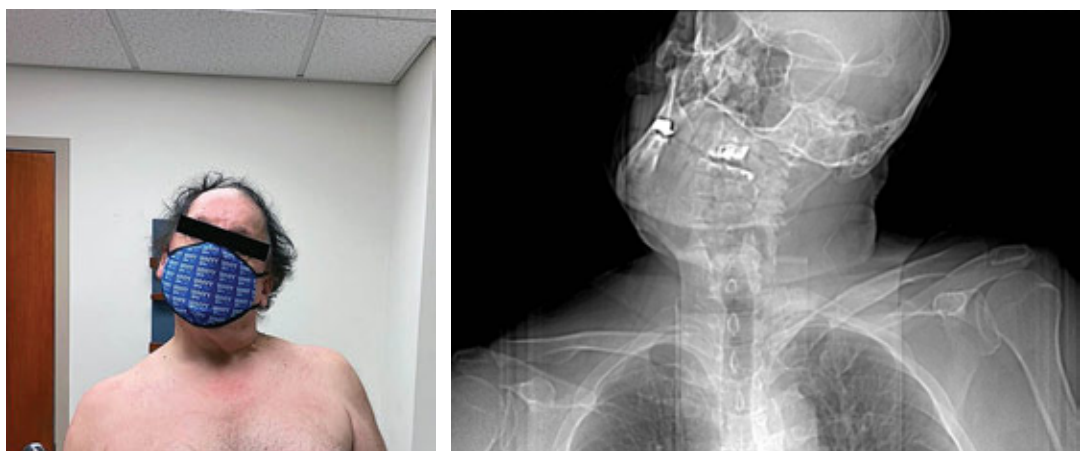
Pre-operative clinical photo and scout CT image demonstrating the classic “Cock-Robin” posture, with the head yawed to the right and rolled to the left.
